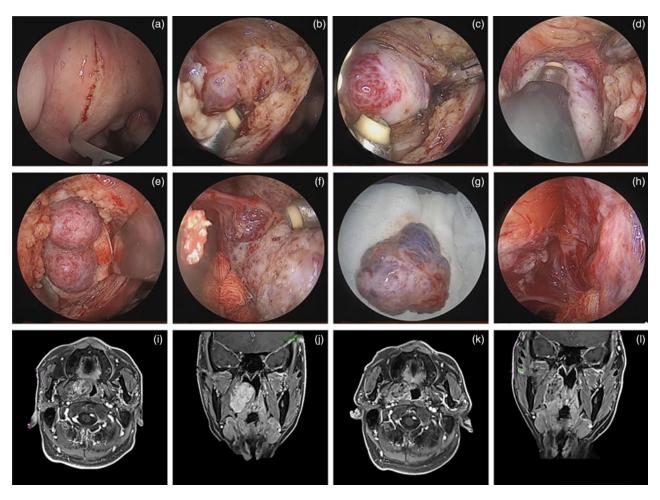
(a–f) Images of the surgical procedure using the endoscopic transoral approach to the parapharyngeal space (example of case 1: en-bloc excision of a haemangioma); (g) endoscopic image showing completely resected haemangioma; (h) endoscopic image of the operative cavity after tumour removal; pre-operative enhanced magnetic resonance imaging (MRI) scans in the (i) axial and (j) coronal planes; and post-operative enhanced MRI scans in the (k) axial and (l) coronal planes.
